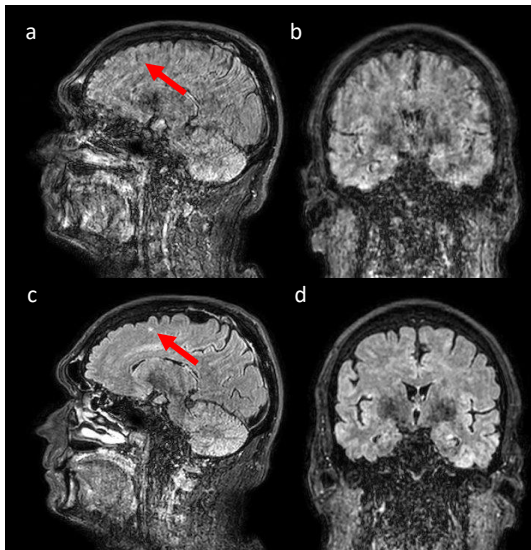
T1-weighted 3D IR-TFE scan of subject with large pose changes during scan. (a/b) Scan without PMC. (c/d) Scan with PMC enabled. The reduction of motion artifacts reveals a white matter lesion previously obscured.
